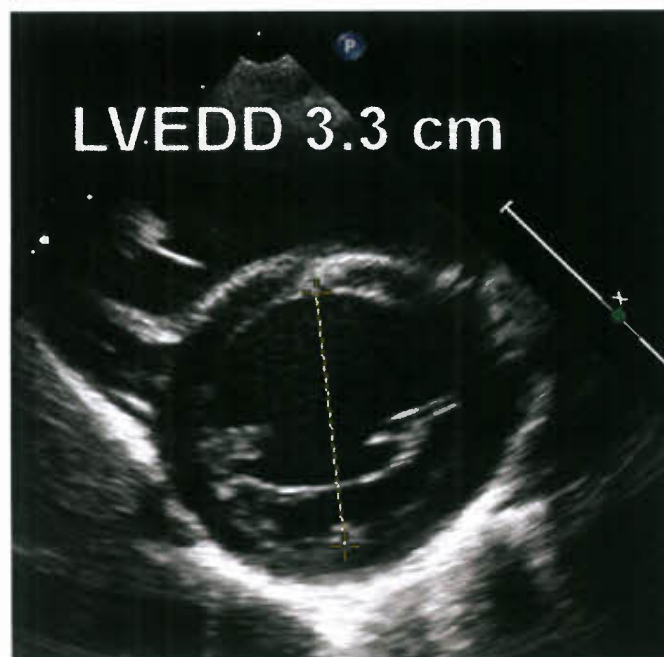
Two-dimensional measurement of LV dimensions. The left ventricular end-diastolic dimension (LVEDD) is measured from a parasternal short-axis view just inferior to the mitral valve leaflets.
